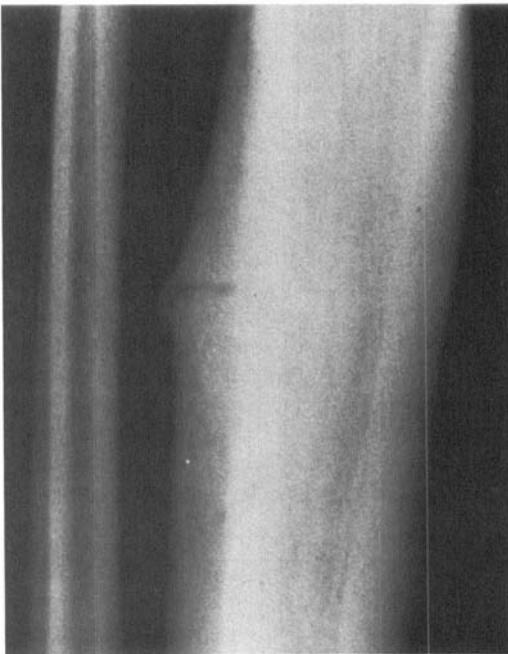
A-P radiograph of the mid-tibia showing a transverse stress fracture.
